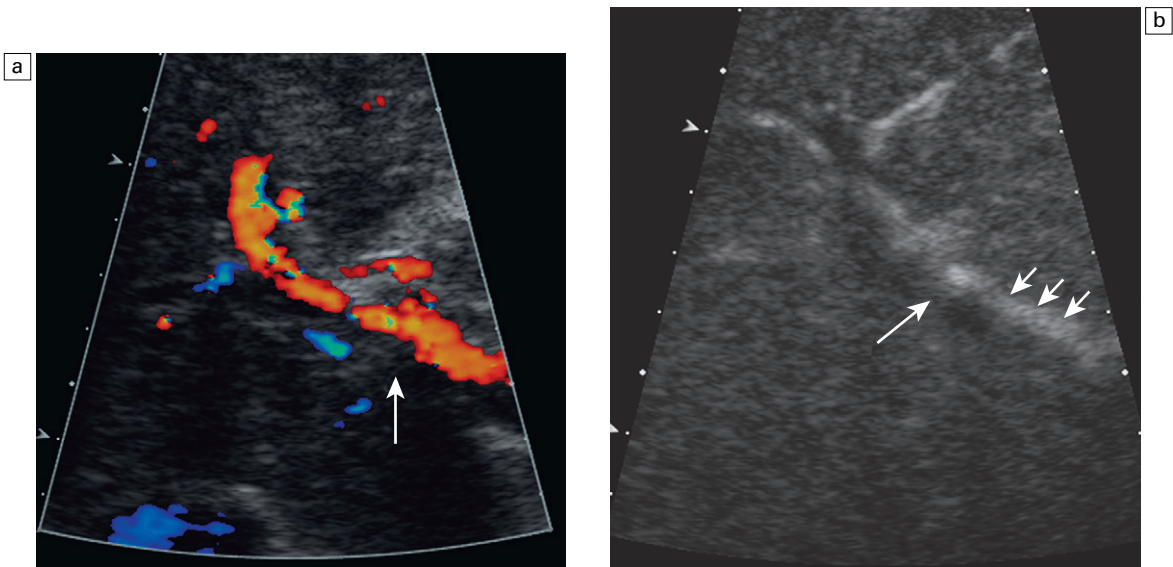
Demonstration of portal vein patency status is improved by the use of microbubble contrast, ‘Doppler rescue’; (a) on baseline imaging there is no colour Doppler signal from the portal vein (arrow) but flow is seen in the hepatic artery; (b) following administration of SonoVue®, and using CCI® (Acuson Siemens, low mechanical imaging) contrast is seen in the hepatic artery (small arrows) but no contrast is present in the portal vein (arrow), confirming occlusion.
